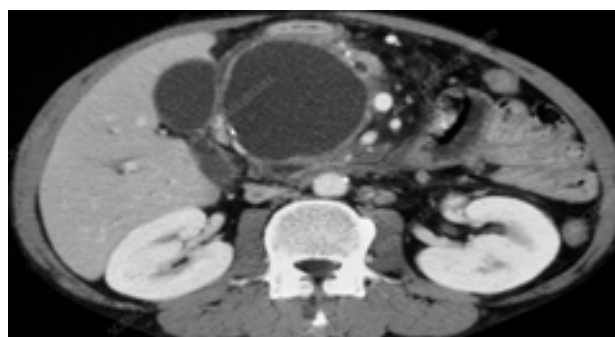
Contrast-enhanced CT scan abdomen revealing pancreatic pseudocyst
